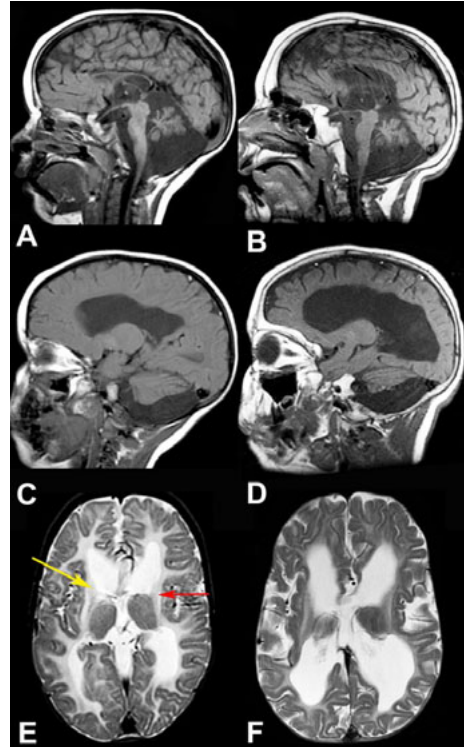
Extensive MRI abnormalities.
